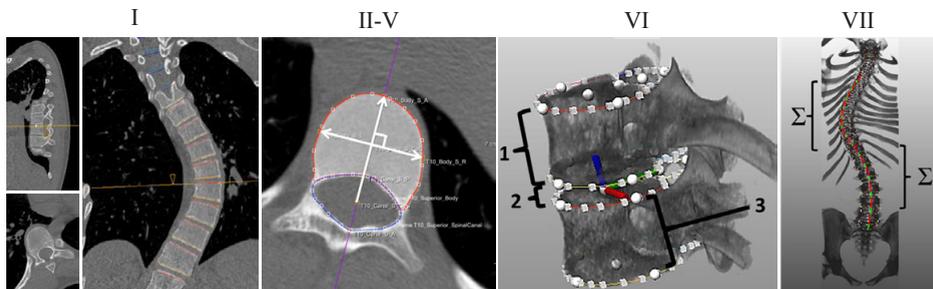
The image processing technique for semi-automatic analysis of the 3-D morphology of the vertebrae and intervertebral discs on high resolution computed tomography scans of adolescent idiopathic scoliosis patients consisted of six-steps as described in the methods section. After delineation of the orientation of the inferior and superior endplates in 3-D (I), true transverse sections of each individual endplate were reconstructed. Based on the center of mass of segmentations of the endplate and spinal canal, the anterior-posterior ('endplate-vectors') and right-left axes were calculated (II-IV). Using these vectors, mechanical torsion as well as anterior-posterior and right-left asymmetry (V) were computed for all intervertebral discs and vertebral bodies in the thoracic and (thoraco)lumbar curve (VI). 1=anterior vertebral body height, 2=anterior intervertebral disc height, 3=height of the left side of the vertebral body.
